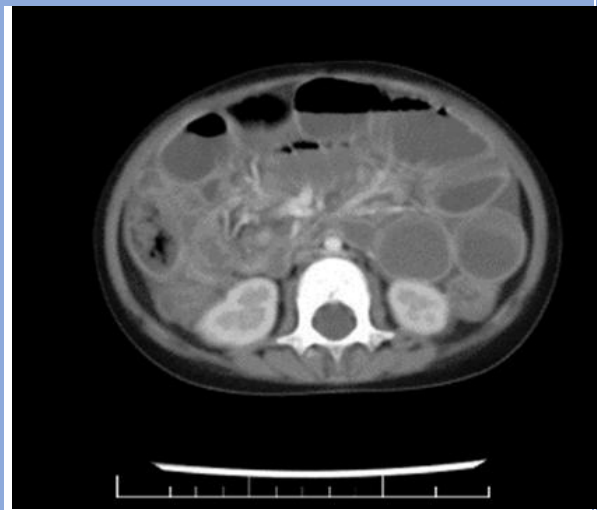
A CT scan abdomen and pelvis image, showing multiple dilated small bowel loops.
